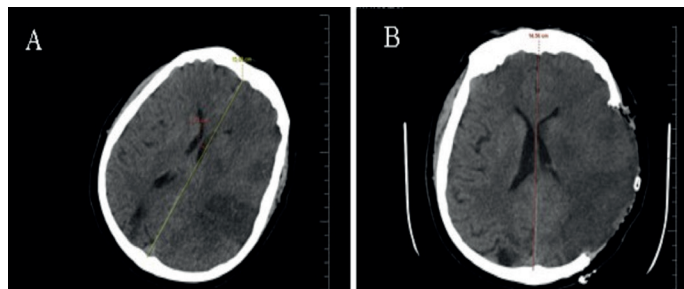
Axial brain computed tomography images of (A) the preoperative midline shift (13.80 mm) and (B) postoperative improvement in the midline shift
